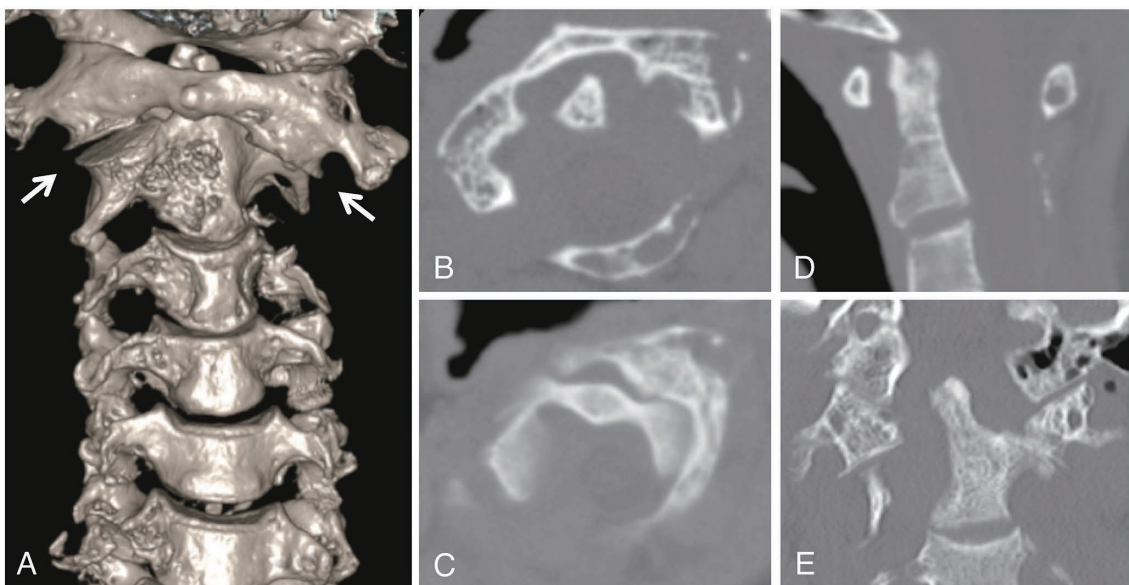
3D-CT and axial plane images of the upper cervical spine one month after admission. Osteolytic changes were in progress in the C1 lateral mass, the dens, and the posterior part of C2 to C5, and the atlanto-axial joint showed a rotatory dislocation (arrows) (A: 3D-CT; B, C: axial planes; D: sagittal plane; E: coronal plane).
